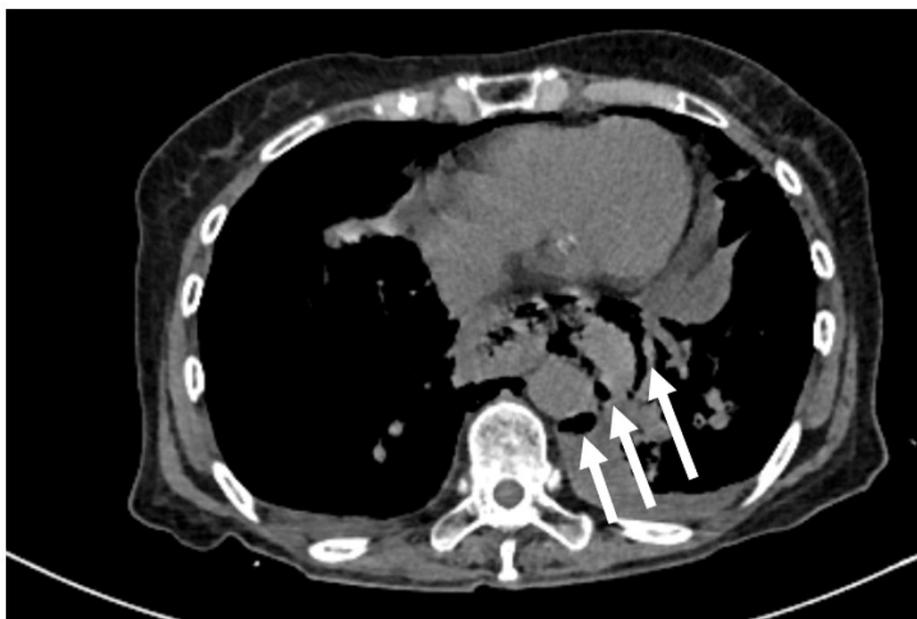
Chest CT Scan. Presence of extraluminal air in the posterior mediastinum (white arrows) suggestive of esophageal wall discontinuity, indicative of pneumatosis of the esophageal wall and pneumomediastinum.
